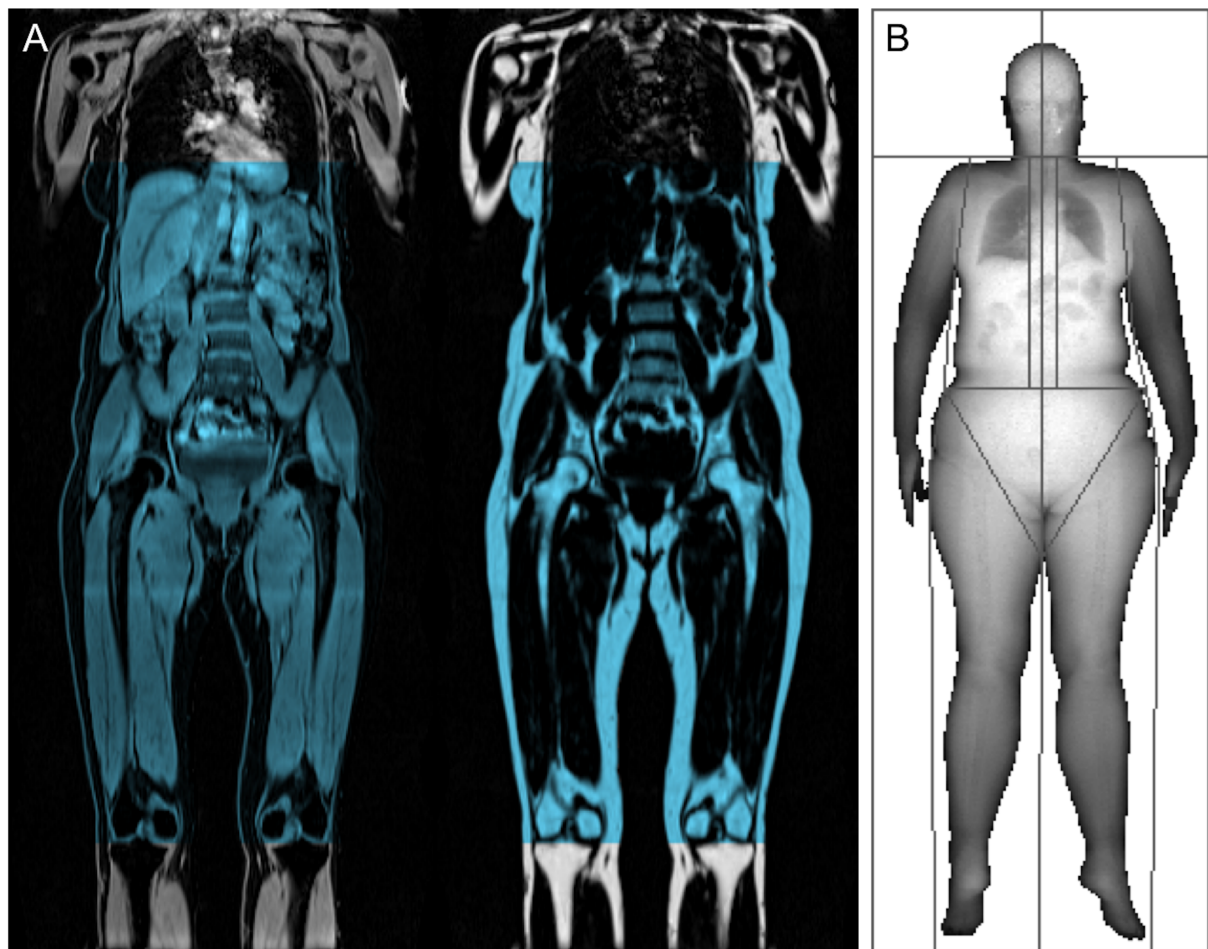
A: The definition of lean and adipose tissue measured by MRI from the bottom of the thigh muscles to top of vertebrae T9 marked in blue color in the water (left) and fat (right) image. B: An example of a DXA image from the study cohort. (DXA image copyright UK Biobank. Reprinted with permission.)
